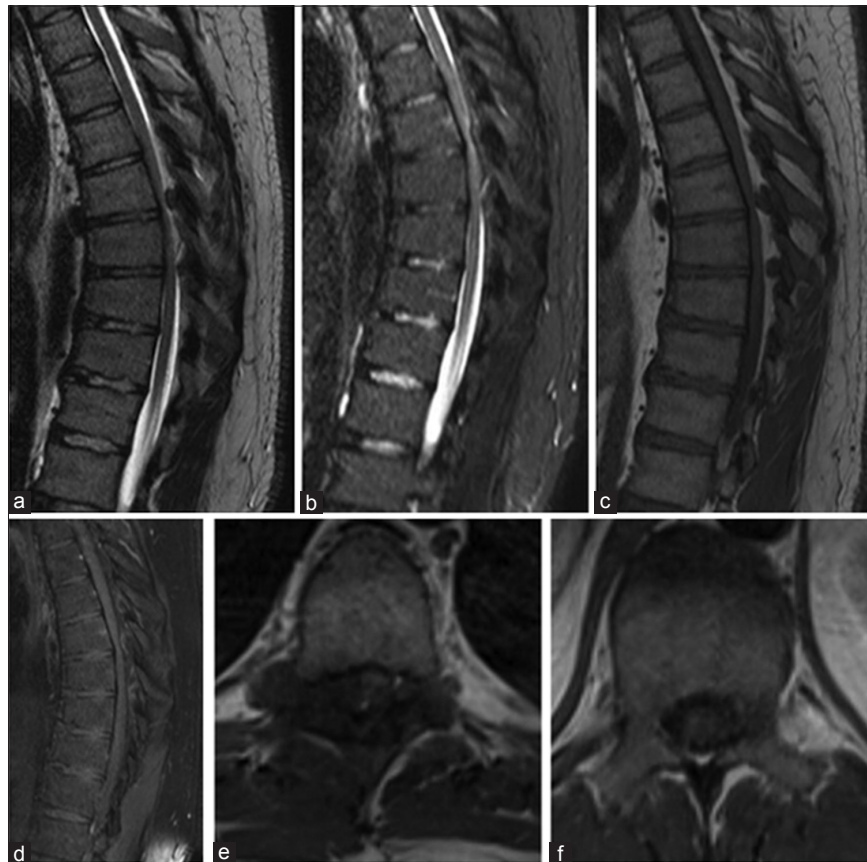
Magnetic resonance imaging (MRI) images with the right lateral epidural abnormality in the mid-thoracic spine with spinal cord compression. (a) Sagittal T2 sequences, (b) sagittal short-tau inversion recovery sequences, (c) sagittal T1 sequences without contrast, (d) sagittal T1 sequences with contrast, (e) axial T1 MRI with contrast demonstrating extension of a tophus into the spinal canal and compressing the spinal cord to the left, (f) axial T1 magnetic resonance imaging with contrast at a level with no inflammatory or degenerative changes and no spinal cord compression.
